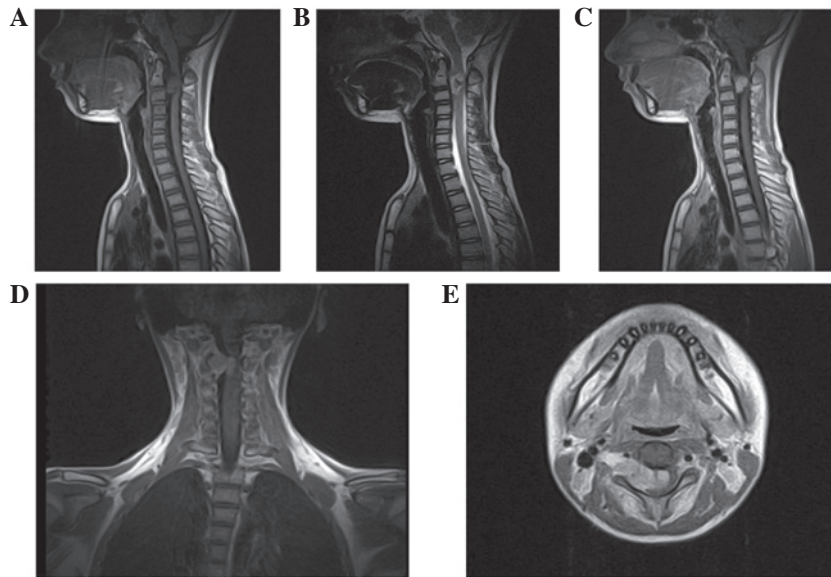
Pre-operative MRI revealing an intraspinal extramedullary lesion at the C2-3 level with (A) isointensity on the sagittal T1-weighted image and (B) mixed hyperintensity on the sagittal T2-weighted image. Gadolinium-enhanced (C) sagittal, (D) coronal and (E) axial T1-weighted MRI revealing that the mass extended through the enlarged C2-C3 neural foramen, compressing and partially encompassing the right vertebral artery, with irregularly heterogeneous enhancement. MRI, magnetic resonance imaging.
